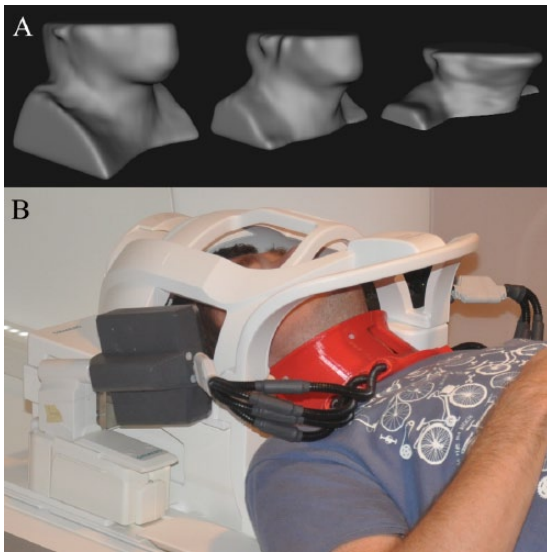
Neck-shape-specific coils. (A) Standard neck coils with a large all-encompassing anterior neck coil are made to accommodate all patient shapes and sizes at the expense of poor signal-to-noise ratio (SNR). (B) The standard magnetic resonance imaging head/neck coil can be fitted with a 7-channel neck-shape-specific coil that fits close to the surface of the neck. This provides significantly higher SNR than the commercial coil alone.
